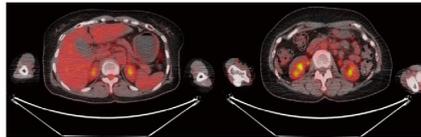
(B) of Case 1 : PET/CT images about 1 year after 18 cycles of palliative chemotherapy reveals nearly complete response of primary AGC and its metastatic lymph nodes.
